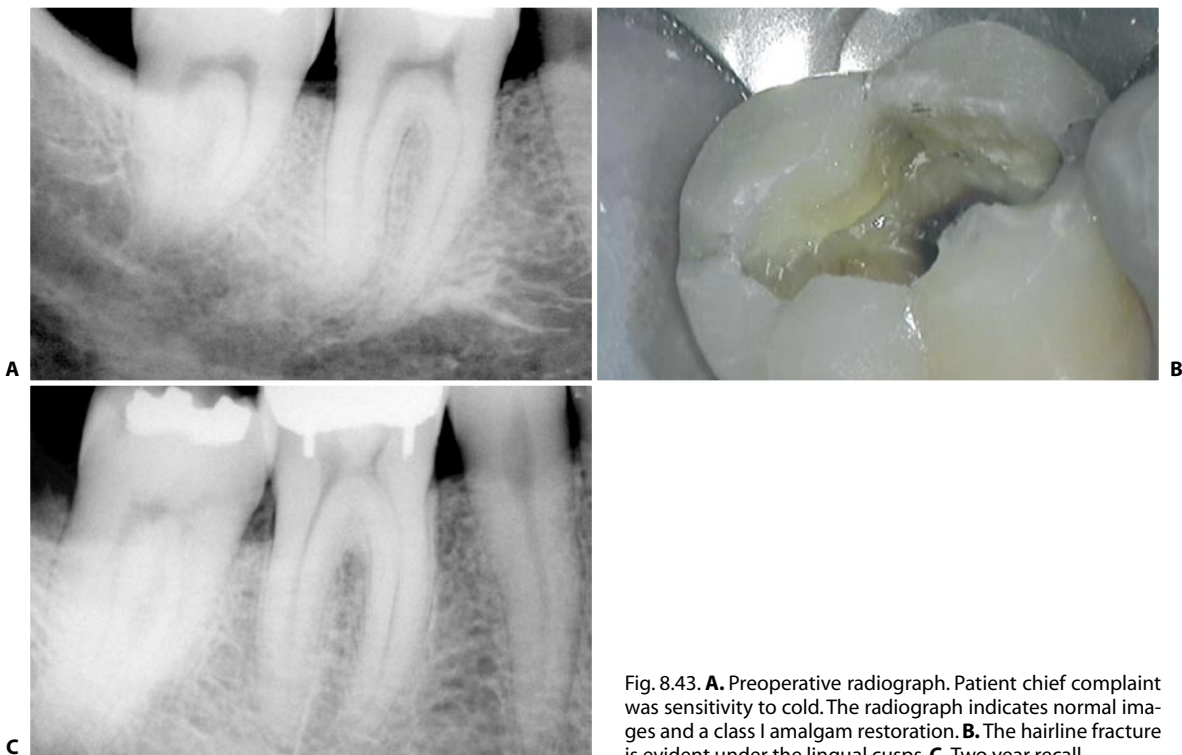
A. Preoperative radiograph. Patient chief complaint was sensitivity to cold. The radiograph indicates normal images and a class I amalgam restoration. B. The hairline fracture is evident under the lingual cusps. C. Two year recall.
